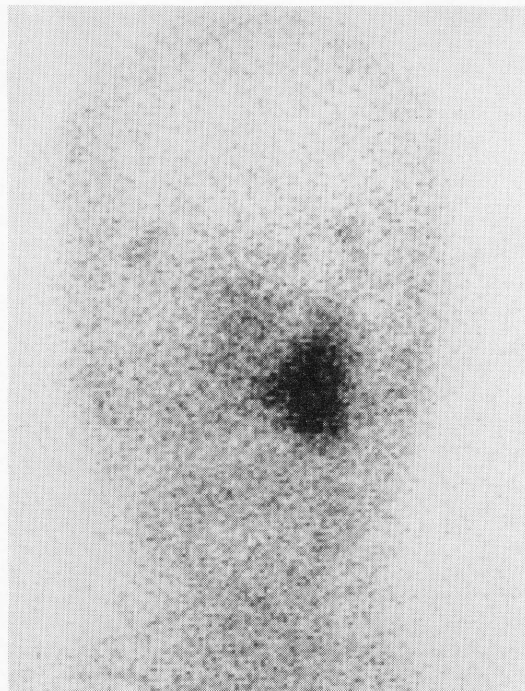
Spot image of the head in gallium scintigraphy showed a high uptake in the lesion as well.
